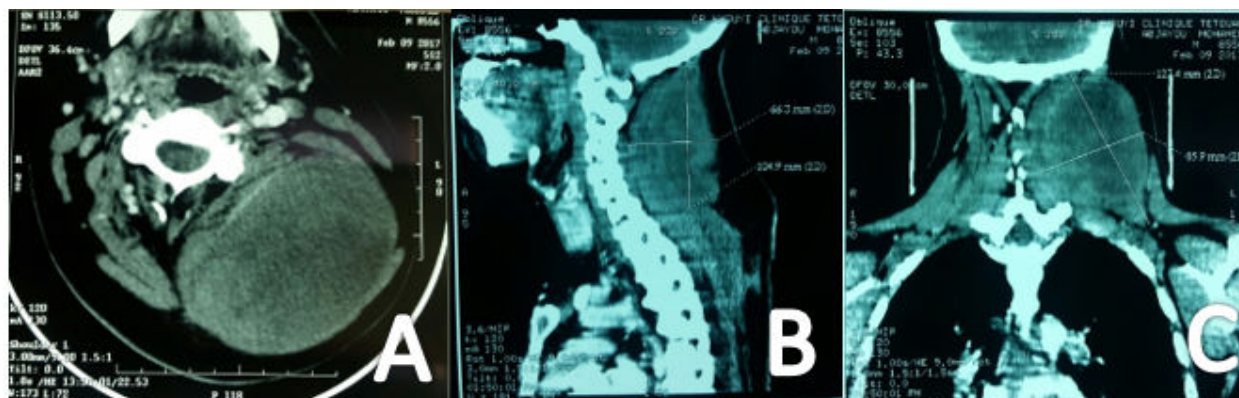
Different planes of CT scan showing the cervical mass (A: Axial plane, B: Sagittal plane, C: Frontal plane).
